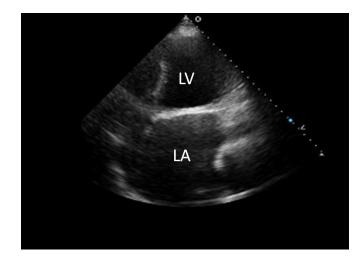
Apical 2-chamber view of a heart transplantation candidate demonstrating a giant left atrium (LA). The LA diameter measured in this patient was 15 cm, with a corresponding circumference >45 cm. LV indicates left ventricle.
